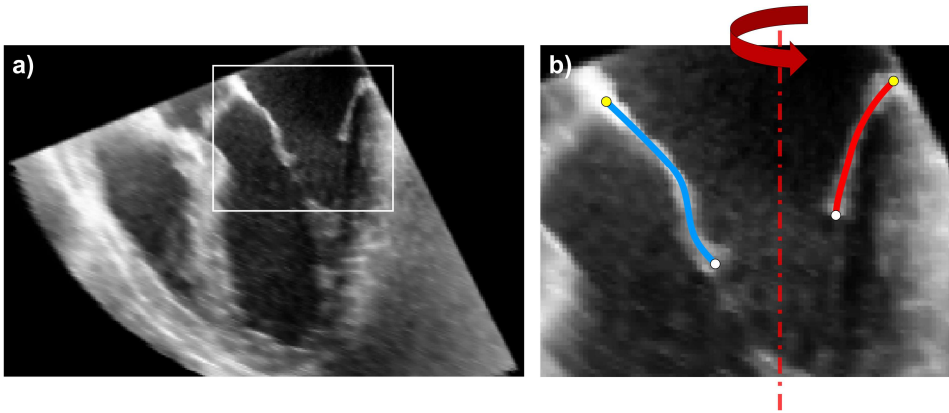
Segmentation of the mitral valve structure from echocardiographic images: a) extraction of the region of interest; b) manual tracing of anterior (blue line) and posterior (red line) leaflets, mitral annulus (yellow dots) and free margin (white dots)
